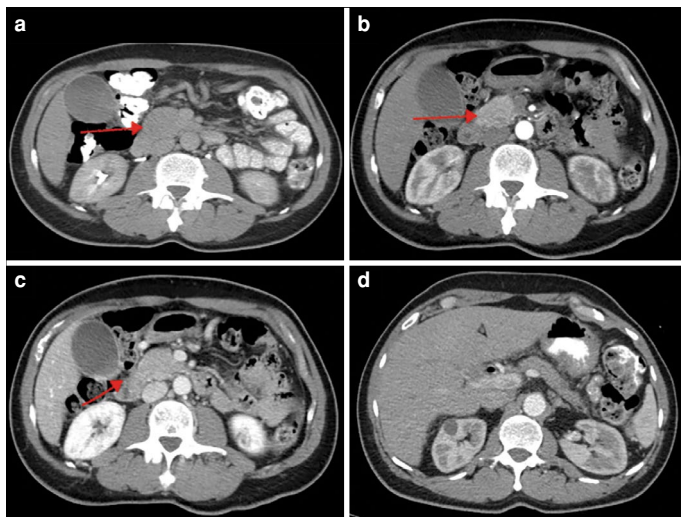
(a) CT abdomen/pelvis with IV/PO contrast showing increased fullness to the pancreatic head with a hypo-enhancing mass-like lesion measuring up to 3 cm. (b, c) CT triple phase liver showing hypervascular arterial enhancing pancreatic head mass measuring up to 3.6 X 2.6 X 5.5 cm in the largest dimensions. (d) Compared with prior studies (previous images), the pancreas is no longer swollen and edematous, but appears somewhat atrophic. No definite enhancing masses are seen in the head of the pancreas.
